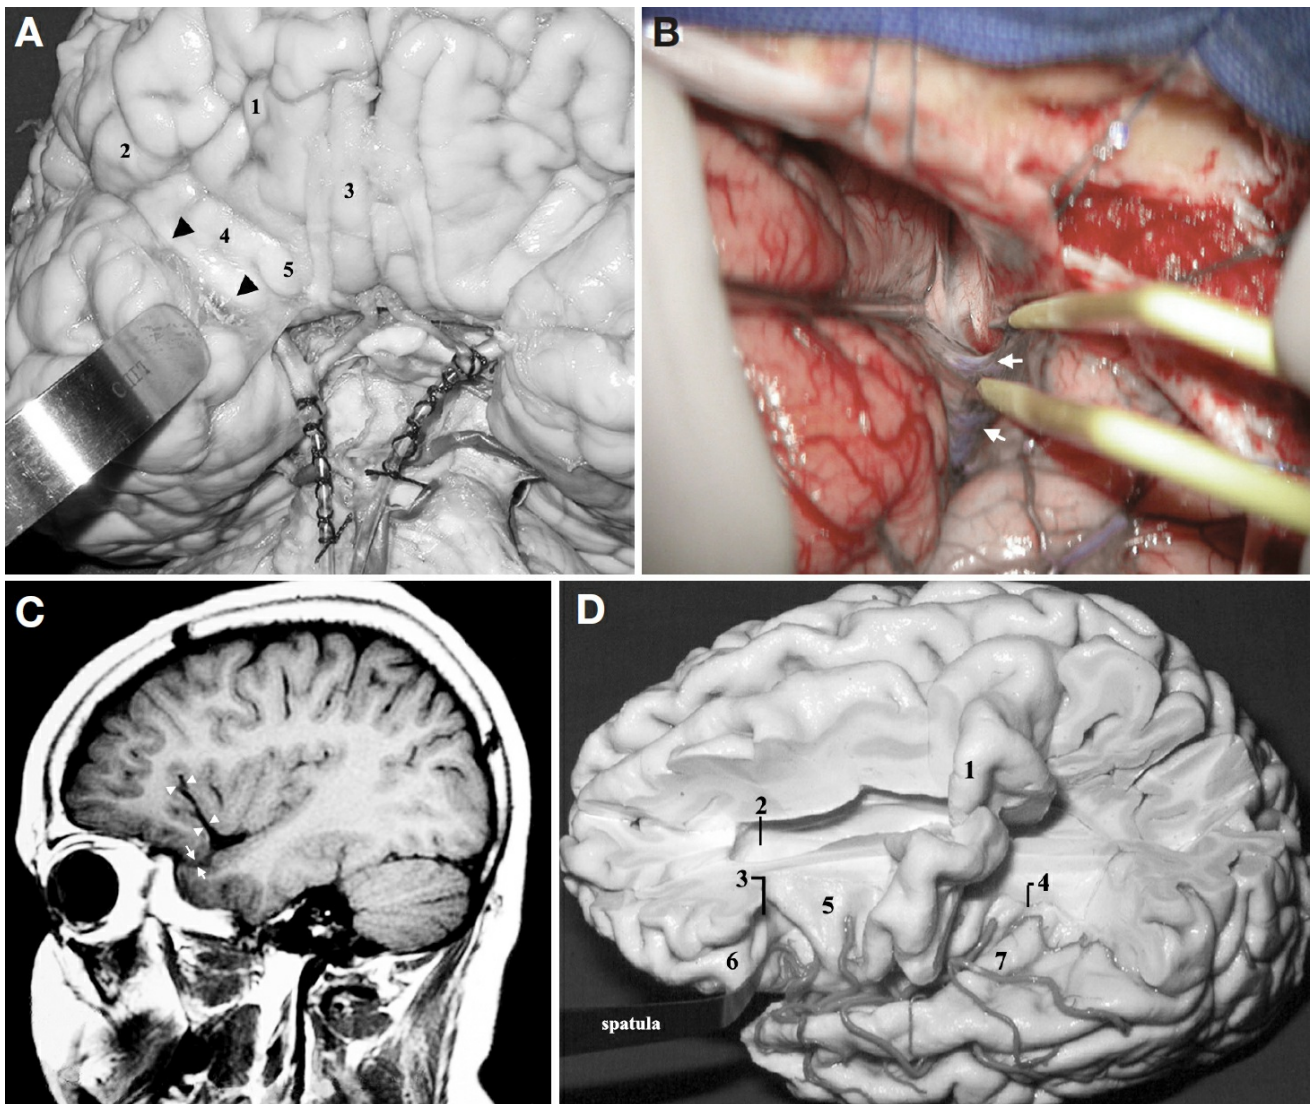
A, anterobasal view of the cerebrum. The arrowheads indicate the frontotemporal arachnoid reflection bridging the orbital surface of the frontal lobe to the planum polare. 1, anterior orbital gyrus; 2, lateral orbital gyrus; 3, rectus gyrus; 4, posterior orbital gyrus; 5, medial orbital gyrus. B, intraoperative photograph showing the basal surface of the right hemisphere after the pterional craniotomy and dural opening. The frontotemporal arachnoid membrane (arrows) in this figure has been stretched between the tip of the bipolar forceps and the suction tube. The frontotemporal arachnoid membrane is continuous with the carotid, chiasmatic, and olfactory cisterns. In this figure, the olfactory tract is shown at the right side of the tip of the suction tube, and the optic nerve is shown at the right side of the olfactory tract. C, sagittal MRI scan. The arrows indicate the intermediate plane of the sylvian fissure on the basal surface, located between the posterior portion of the orbital gyri and the planum polare. The arrowheads indicate the anterior operculoinsular compartment of the sylvian fissure. D, superolateral view of the left
